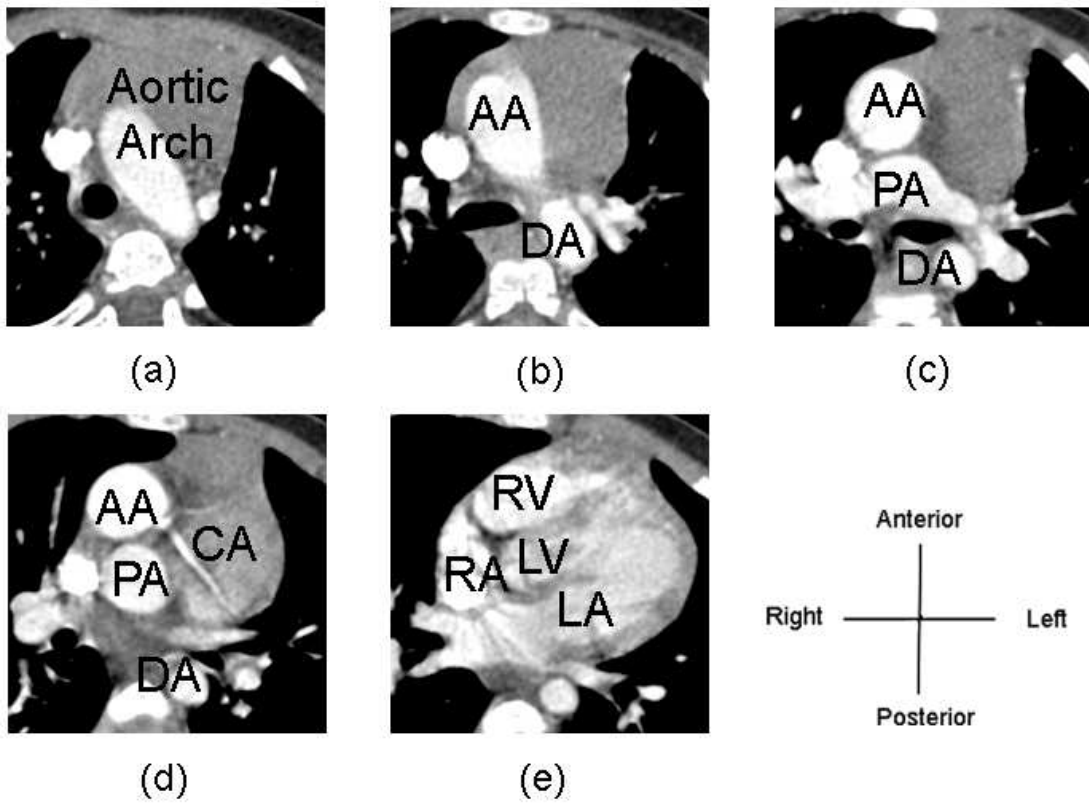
CT images of a patient with TGA. (a)-(e): From top to bottom of the heart. AA: ascending aorta, DA: descending aorta, PA: pulmonary trunk, CA: coronary arteries , LA: left atrium, RA: right atrium, LV: left ventricle, and RV: right ventricle.
